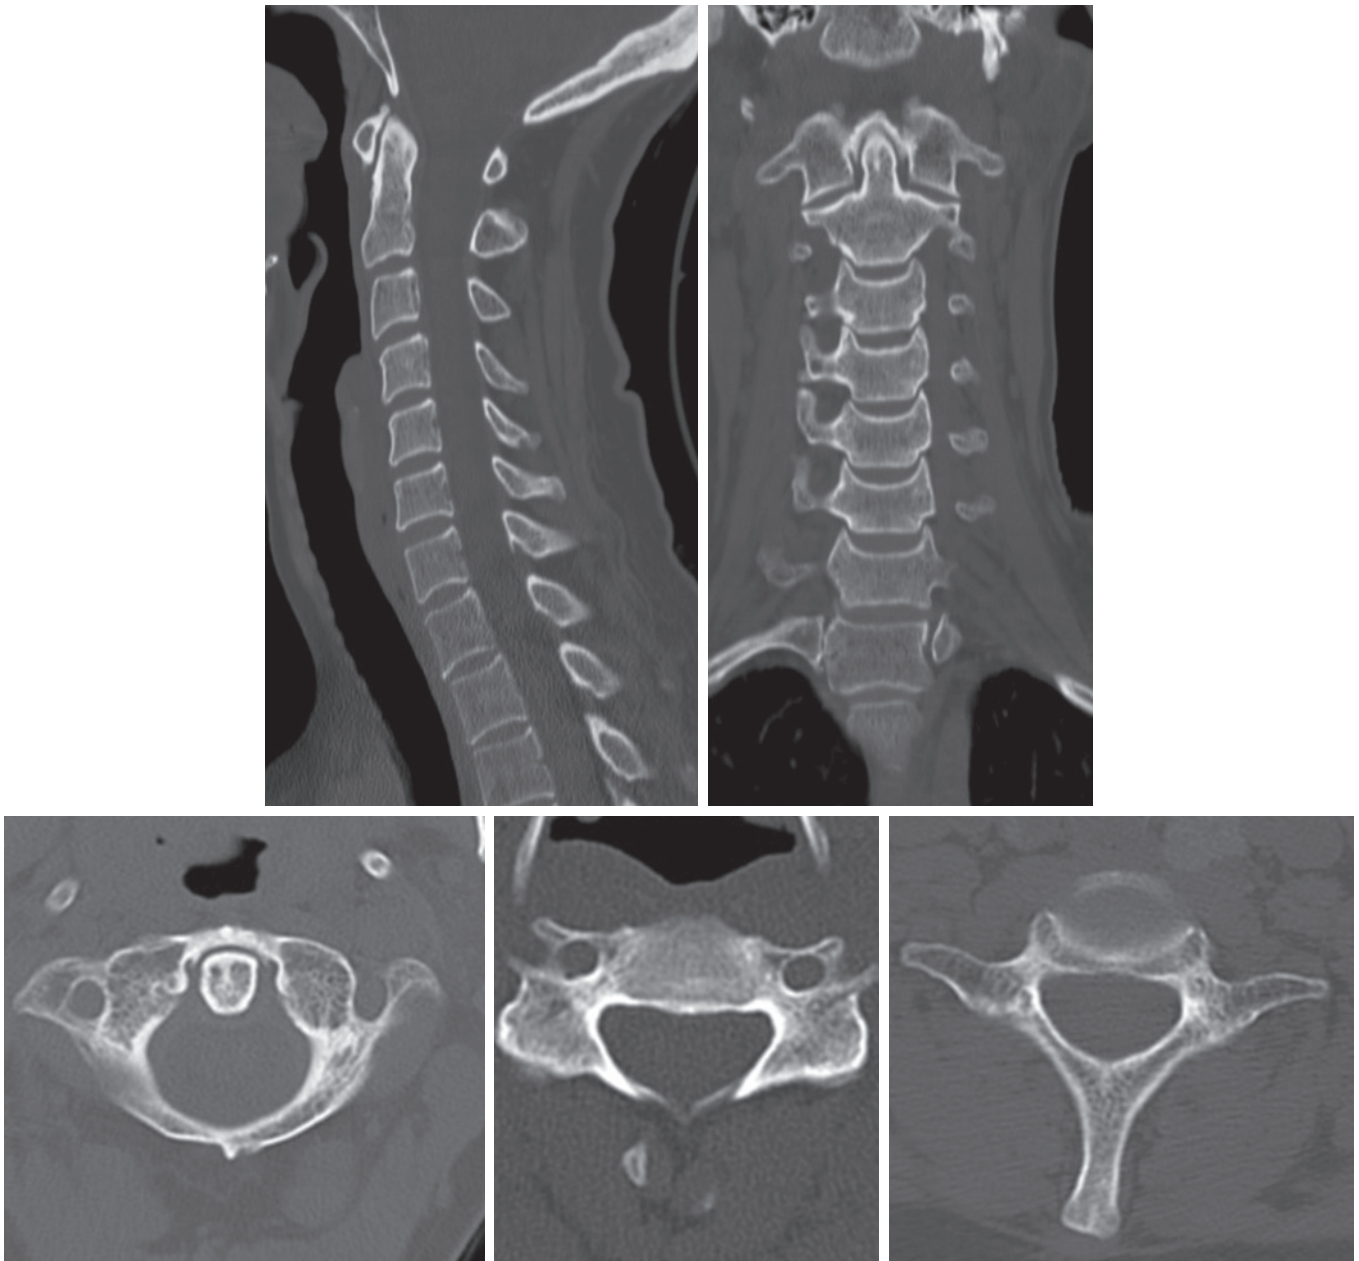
Normal Computed Tomography of the Cervical Spine. Sagittal and coronal reconstructions (*top*). Axial (*bottom row*) images at C1, C4 and C7 demonstrating normal vertebral anatomy.
